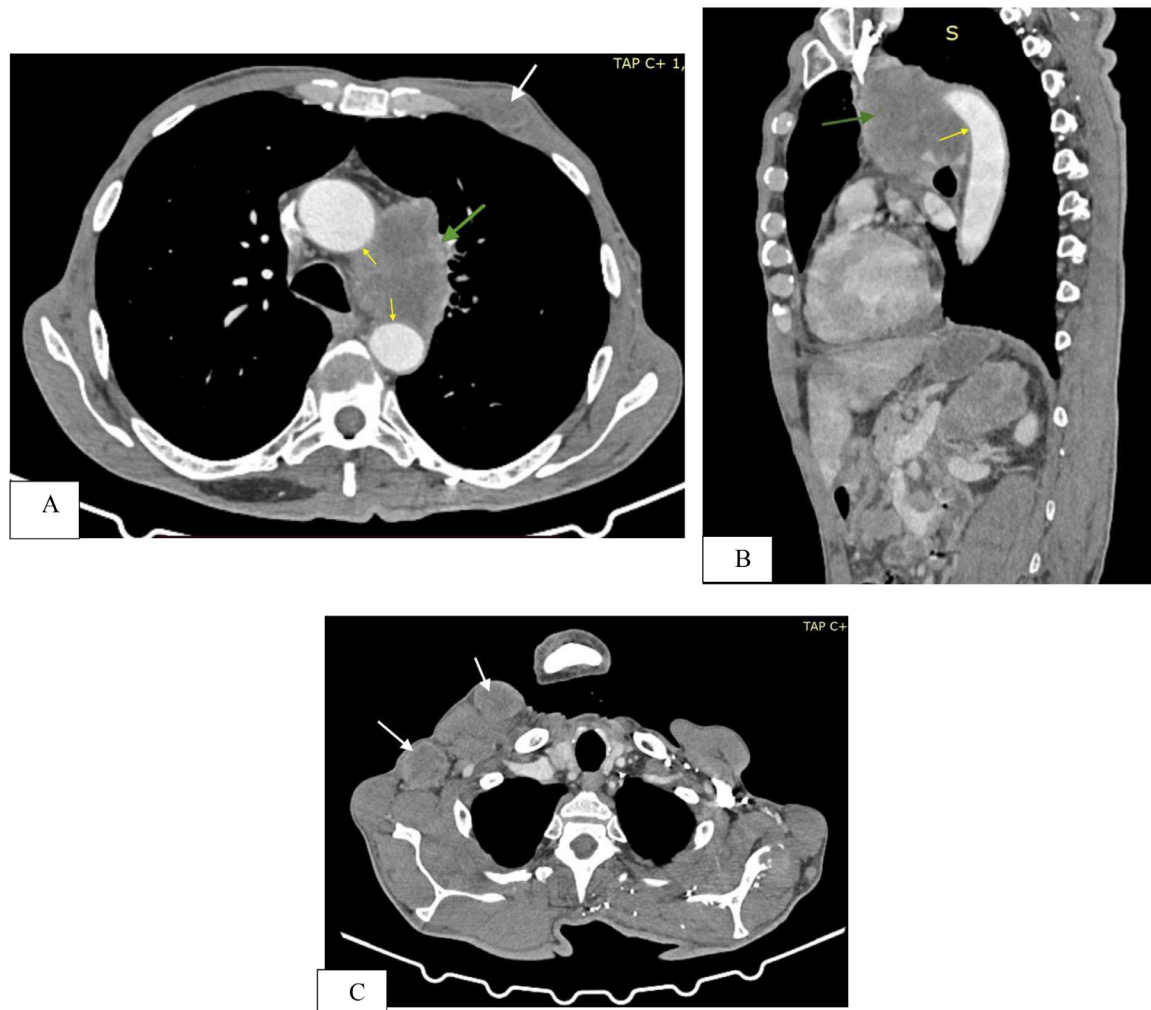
CT scan in portal phase, axial (A) and sagittal (B) images demonstrating a mass of upper and middle left mediastinum (green arrow) coming into contact with the aorta (yellow arrow). (C) CT scan in portal phase, axial image demonstrating bilateral hypodense masses of thoracic soft tissues.
